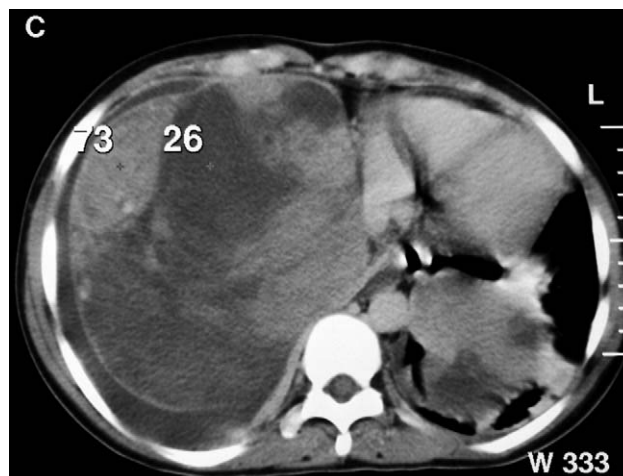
Computed tomography reveals a massive lesion on the right hemithorax involving the mediastinum. A separate mass lesion involving the mediastinum is observed on the left hemithorax as well.
